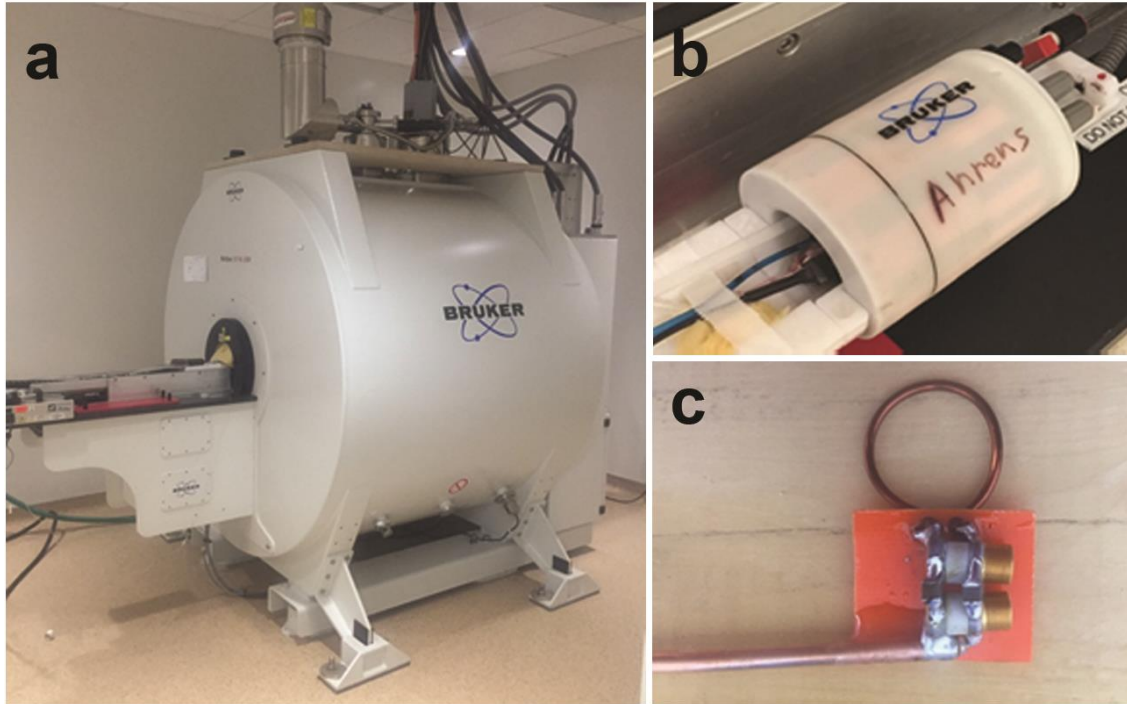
MRI system and coils for *in vivo* imaging. (a) 11.7 T horizontal (16 cm bore) Bruker Biospec preclinical scanner. (b) 40 mm dual-tuned $^1\text{H}/^{19}\text{F}$ birdcage transmit-receive volume coil used for tumor pO_2 measurements. (c) 20 mm custom-built transmit-receive surface coil used for CAR T cell pO_2 measurements.
